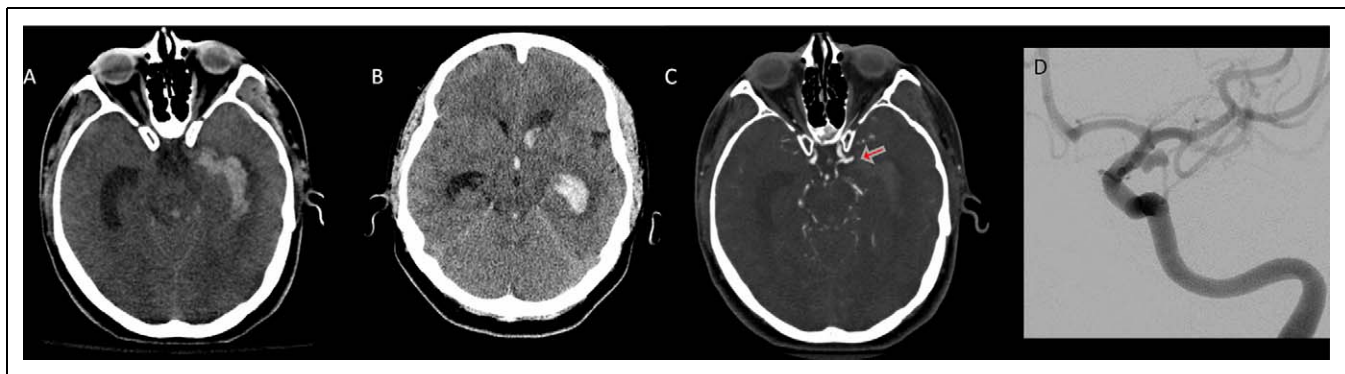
Laterally oriented, ruptured posterior communicating artery aneurysm causing intraventricular hemorrhage. A and B, Intraventricular hemorrhage, predominantly in the left lateral ventricle without significant subarachnoid hemorrhage. C, A computed tomography (CT) angiography revealing a laterally oriented posterior communicating artery aneurysm (arrow) as the etiology of the intraventricular hemorrhage. D, Corresponding digital subtraction cerebral angiography demonstrating the laterally oriented left posterior communicating artery aneurysm.
